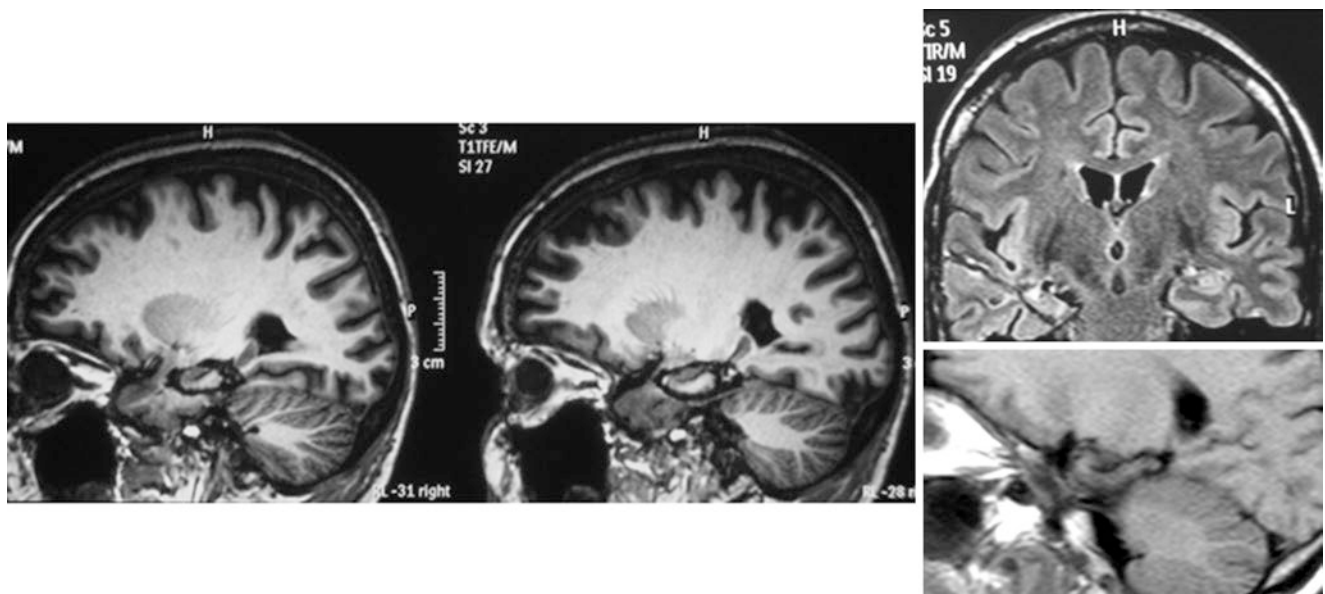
Postoperative MRI after selective amygdalo-hippocampotomy
